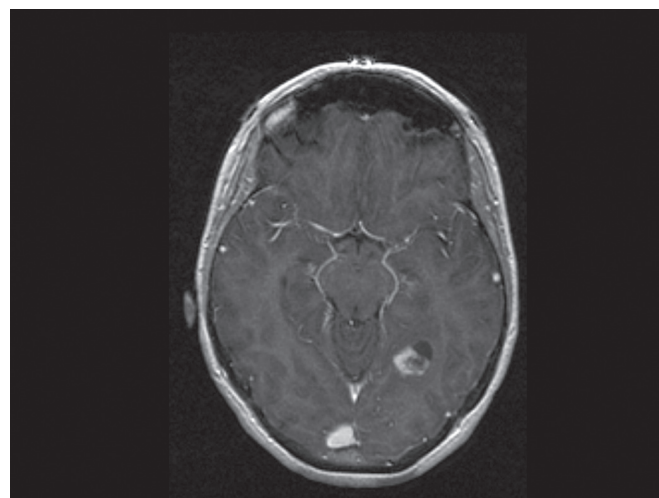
MRI reveals a tumour in the left occipital region in a patient with intractable epilepsy. Pathology revealed a ganglioglioma. There was no recurrence of seizure after resection (sagittal plane T1-weighted image).
